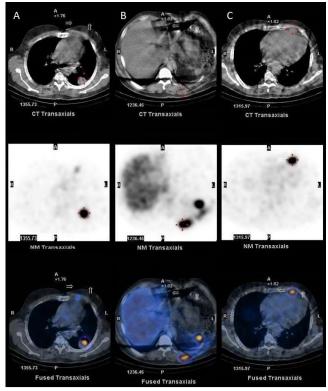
Activity consistent with splenosis foci were observed in CT, SPECT, and hybrid SPECT/CT images in the left upper lobe apicoposterior segment level (a), in the spleen lodge, between the muscle planes of the left posterolateral wall of the thorax (b), and in the anterior parapericardial fatty tissue (c)
